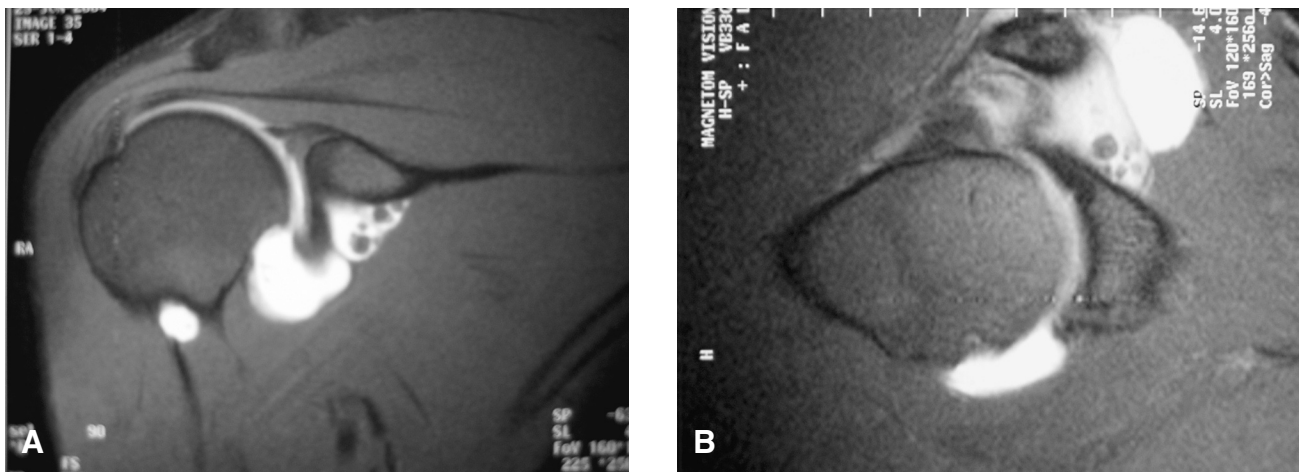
Magnetic resonance images demonstrating loose bodies in the sublabral recess.
